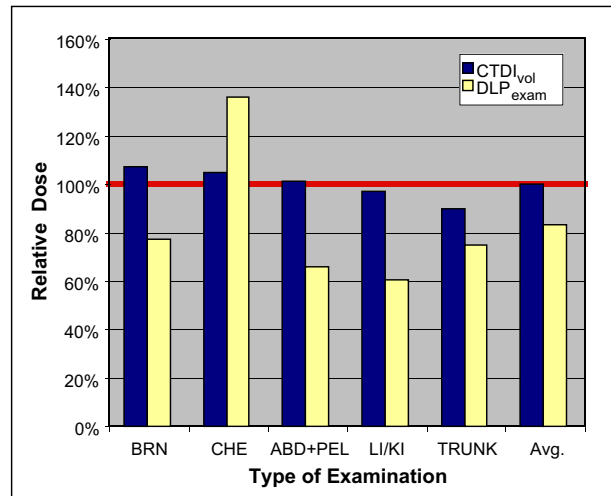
Comparison of the results of the 2003 UK CT survey (multi-slice scanner fraction) with those of the German MSCT survey in 2002. Relative dose values are given for each type of examination in terms of volume CTDI per scan/rotation ($CTDI_{vol}$) and dose-length product per examination (DLP_{exam}). The red line at 100% represents the average of the German MSCT survey in 2002 for the pertaining type of examination and dose descriptor (for abbreviations see tab. 1).
